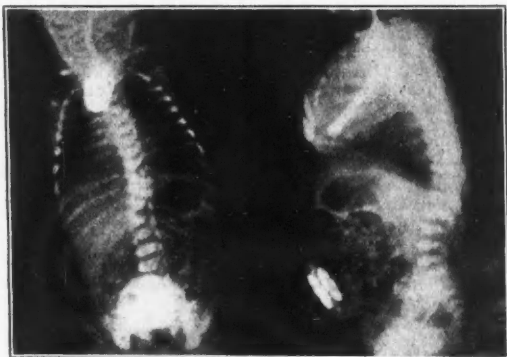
Roentgenograms of Case 1, showing the lipiodol-filled cul-de-sac of the upper esophagus. Note the rounded lower border of the sac, the gas in the stomach and bowel, and anomaly of the lower dorsal vertebrae.
